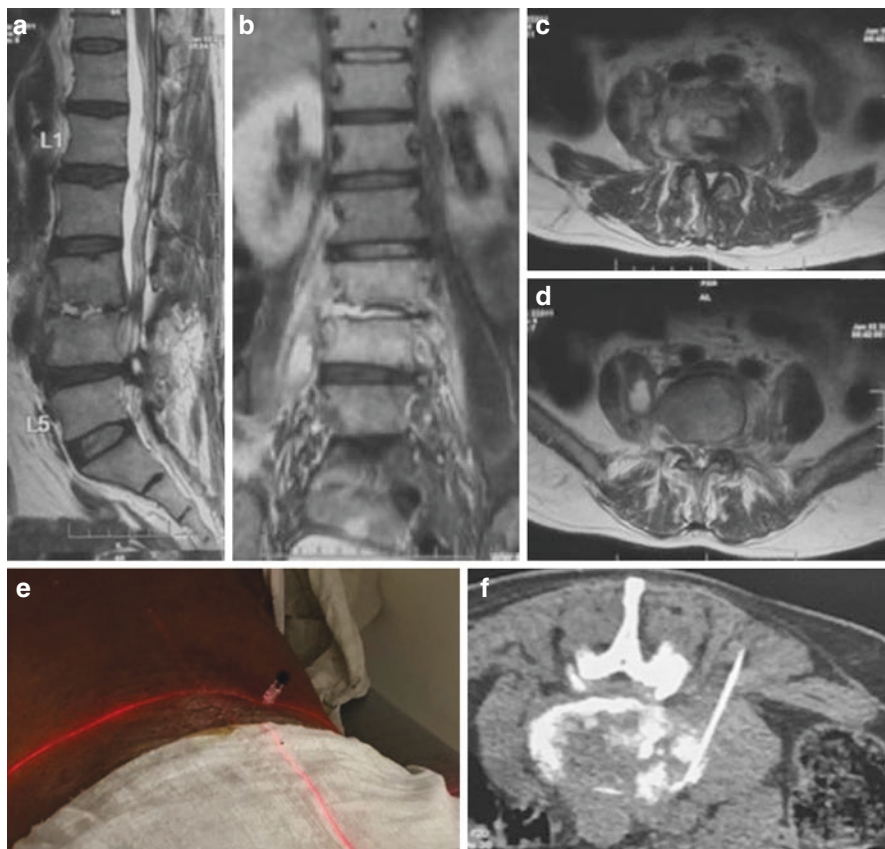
Sagittal T2 (a), coronal T2 fat saturated (b) and axial T2 (c, d) weighted MR images demonstrating spondylodiscitis involving the L3 and L4 vertebral bodies with associated right psoas abscess. Patient lying prone on CT table with needle in situ (e) precisely guided and confirmed by the red laser pointers. Needle in situ evident on the CT image (f)
